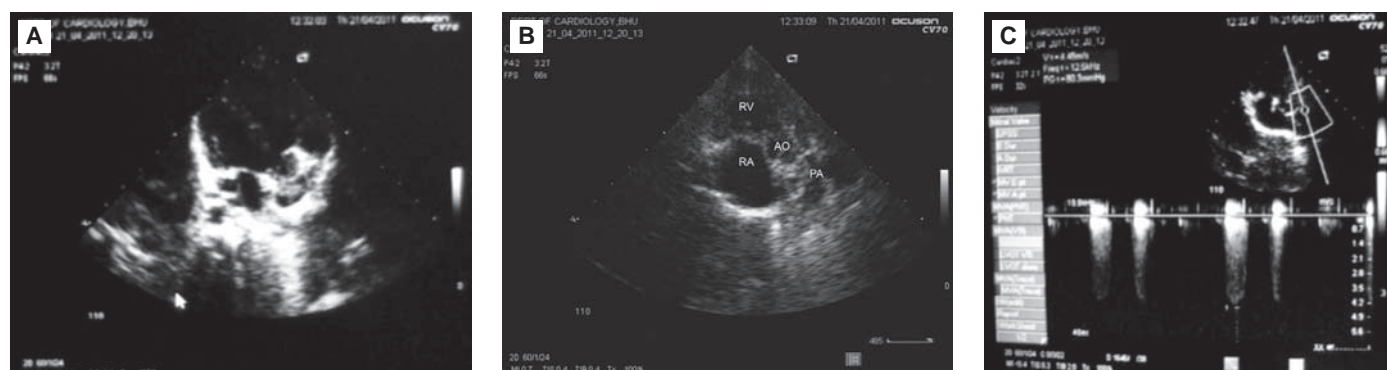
(A) Parasternal long axis view showing overriding of aorta and large perimembranous ventricular septal defect. (B) Parasternal short axis view showing hypoplastic and confluent PA. (C) Continuous Doppler showing infundibular pulmonary stenosis with pressure gradient of 80 mmHg. AO: ascending aorta, PA: pulmonary artery, RA: right atrial, RV: right ventricle.
